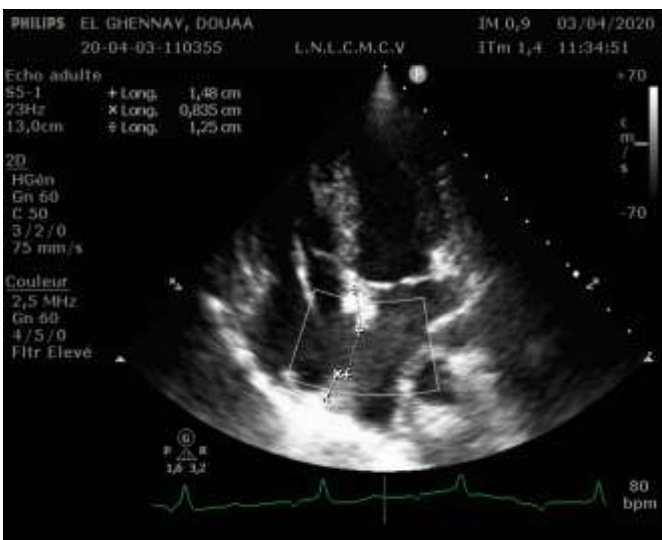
Visualization of the pacemaker probe and interauricular communication in apical four chambers view
